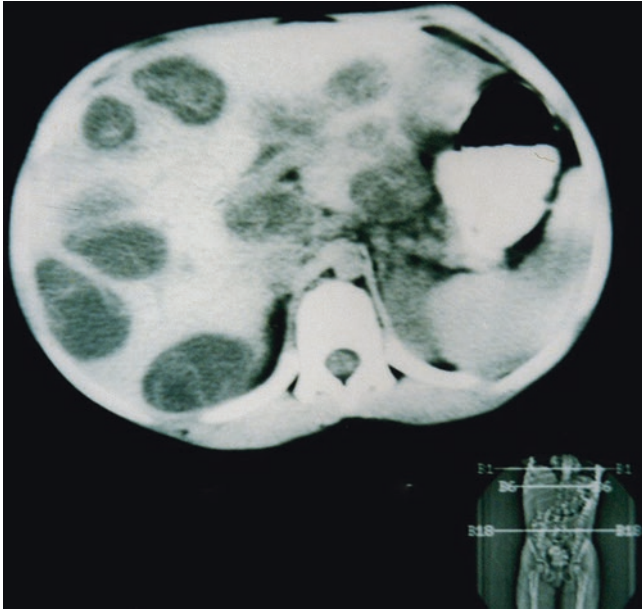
CT of the liver showing multiple large Hydatid cysts in a patient on medical treatment
